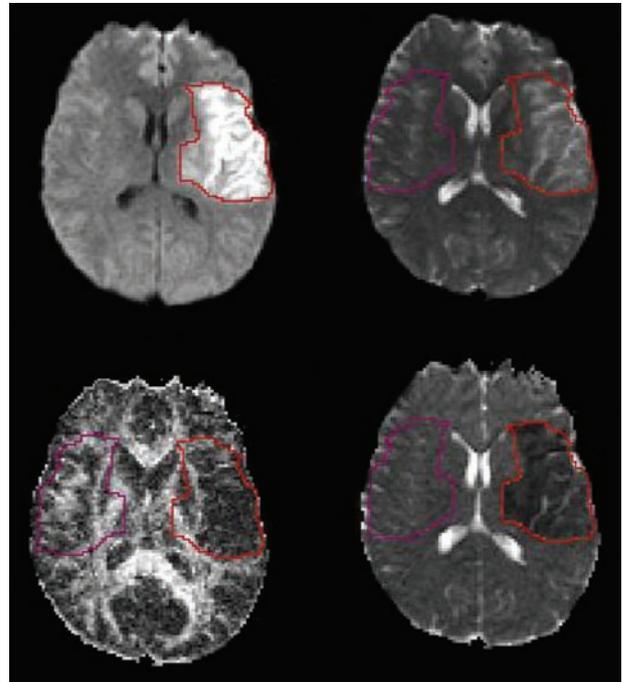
Tracing method for the VOIs. The infarct was outlined on isotropic DWI, section by section, by using a free-hand method. On each section, the ROI was flipped about the vertical axis and placed in the same location on contralateral normal side to obtain a mirror-image ROI. All section ROIs were combined to provide one stroke and one contralateral normal VOI for each patient. All VOIs were projected onto inherently coregistered echo-planar T2WIs, FA maps, and ADC maps. *Top left*, Isotropic DWI. *Top right*, Echo-planar T2WI. *Bottom left*, FA map. *Bottom right*, ADC map.
